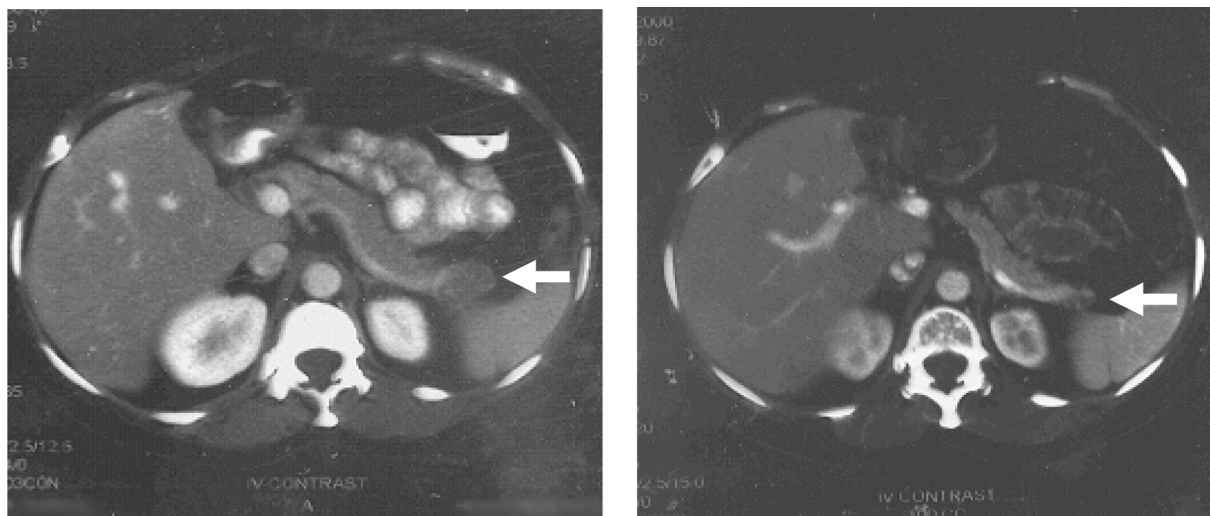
Complete tumour regression of a pancreatic neuroendocrine tumour observed in one individual (Patient 3). Baseline abdominal computed tomography (left) depicting a mass in the pancreatic tail with total resolution (right) following 10 months of combination therapy with Sandostatin LAR[®] and α -interferon. Patient 3 now continues on combination therapy with Sandostatin LAR[®] and pegylated α -interferon.
